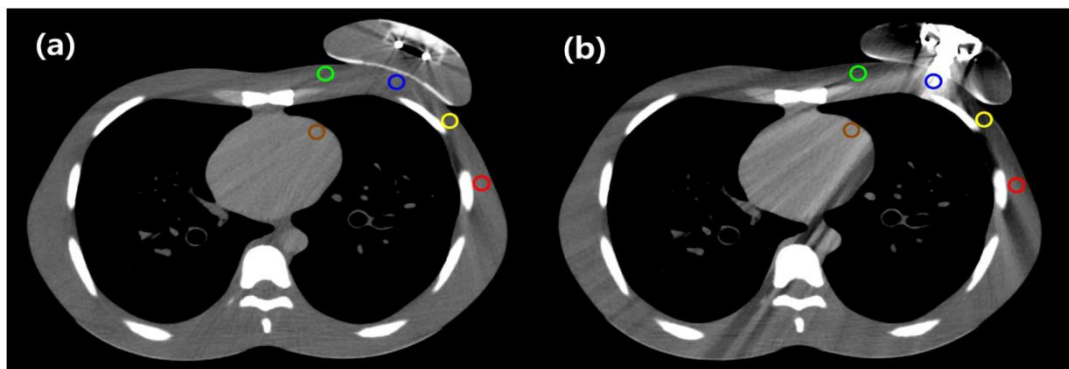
An example of the CT image (a) RFID port, (b) metallic port analysis using the five reference points; point A—central chest wall (blue), point B—medial chest wall (green), point C—lateral chest wall (yellow), point D—axilla (red), point E—left anterior descending artery (brown).
